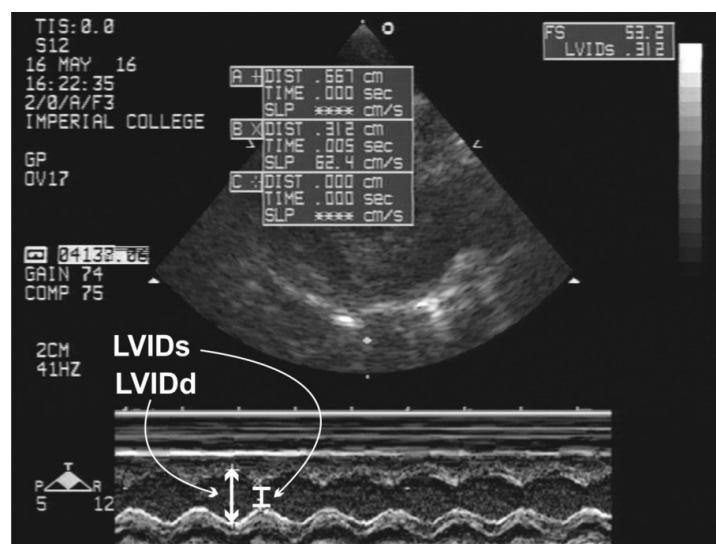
Image of M-mode echocardiography on a GP.
